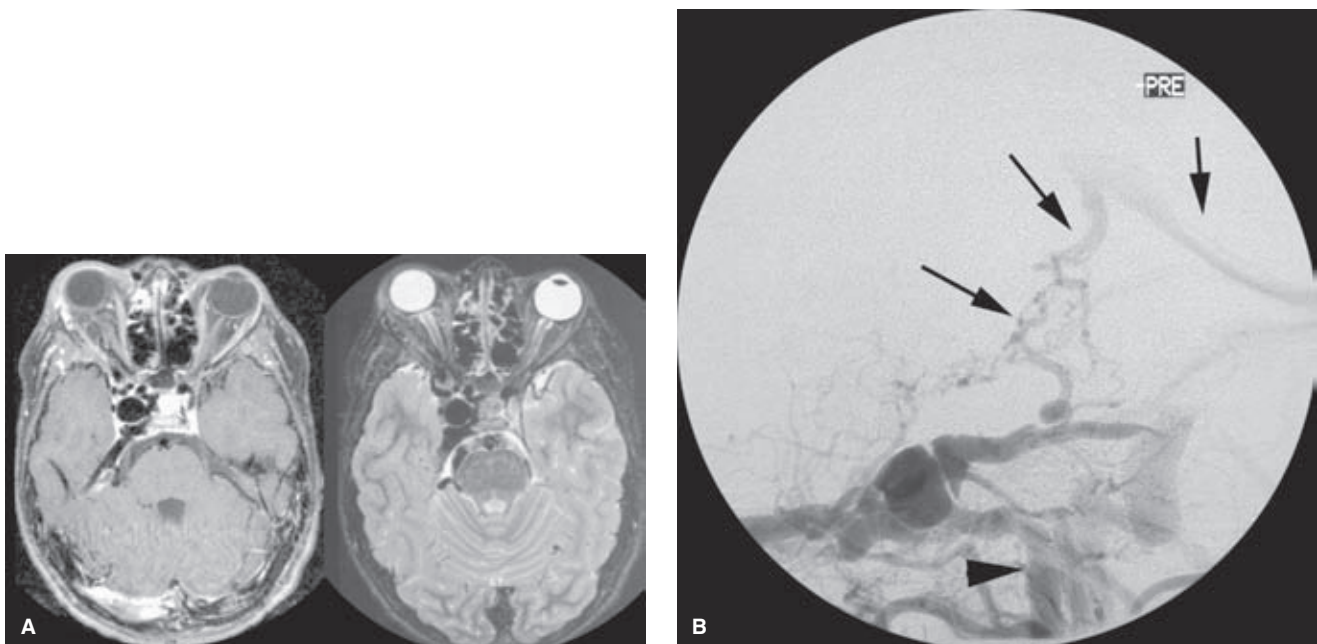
(A-E) CCF in a 14-year-old boy. A teenager sustained severe head injuries when his family car was rear-ended at a traffic light by an inattentive driver. During 6 months of recovery, his right eye became proptotic, and a pulsatile bruit developed. The MRI (A) shows massive distension of the right cavernous sinus and adjacent venous structures. The right carotid artery angiogram (B, lateral view centered on the head) shows no intracranial opacification of arteries beyond the fistula. The right cervical internal carotid artery itself (*arrowhead* in B) is irregular, having been dissected at the time of the original trauma. There is deep venous drainage involving the basal vein of Rosenthal and the veins of the posterior fossa (*arrows* in B). (*continued*)
